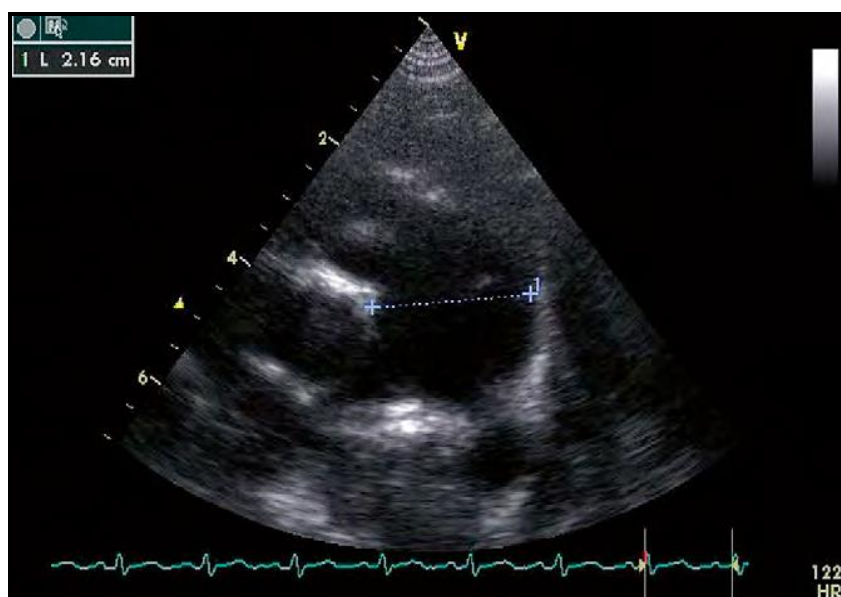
2D echocardiography image showing post-stenotic dilation of the pulmonary trunk. ⁽²⁵⁾
